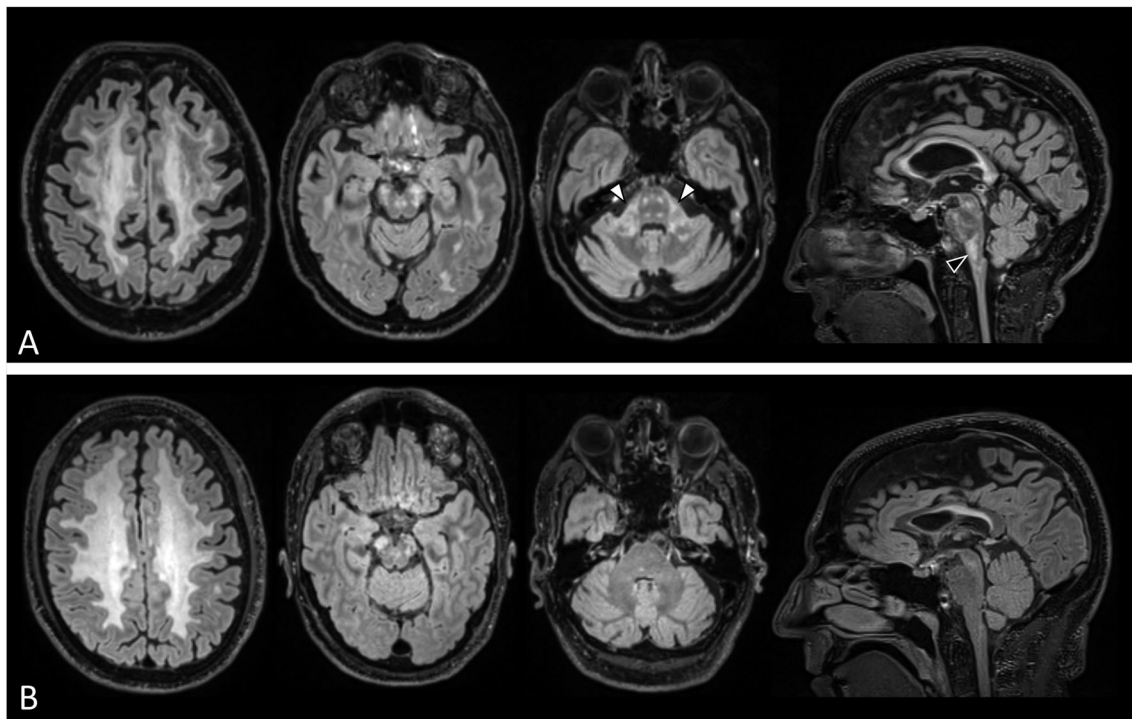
Brain magnetic resonance imaging features in patients with *LMNB1* duplications versus patients with deletions upstream of *LMNB1*. Axial and sagittal fluid attenuated inversion recovery images of a patient with a *LMNB1* duplication (IT6, panel A) and a patient with a deletion upstream of *LMNB1* (delITA A922, panel B). Both participants demonstrate widespread hyperintensity of supratentorial white matter and cerebral peduncles, but only the patient with the *LMNB1* duplication shows involvement of the middle cerebellar peduncles (white arrowheads) and of the bulbar pyramids (black arrowhead).
